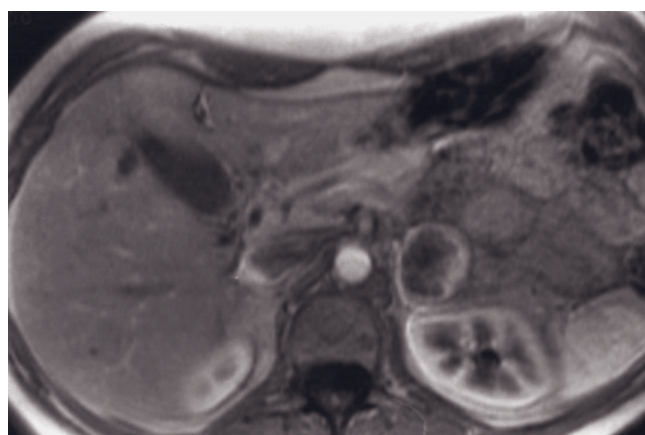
Pheochromocytoma. T1-weighted GE (*a*), T1-weighted out-of-phase GE (*b*), coronal T2-weighted echo-train spin-echo (*c*), T2-weighted echo-train spin-echo (*d*), immediate postgadolinium GE (*e*), and 90-s postgadolinium fat-suppressed GE (*f*) images. A pheochromocytoma is present in the left adrenal, which is mildly low signal intensity on T1 (*a*) and does not drop in signal on the out-of-phase image (*b*). It appears high signal intensity on T2 (*c*, *d*), and after gadolinium administration there is
